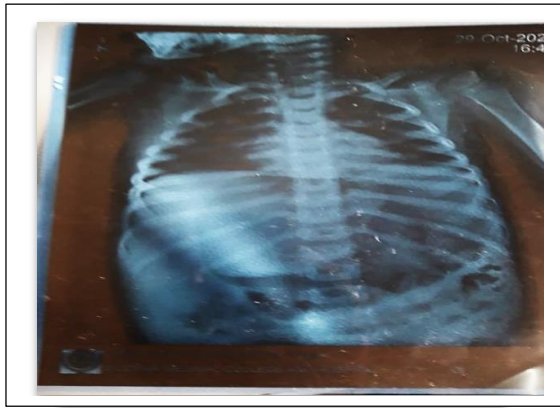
Radiograph showing dilated bowel.
